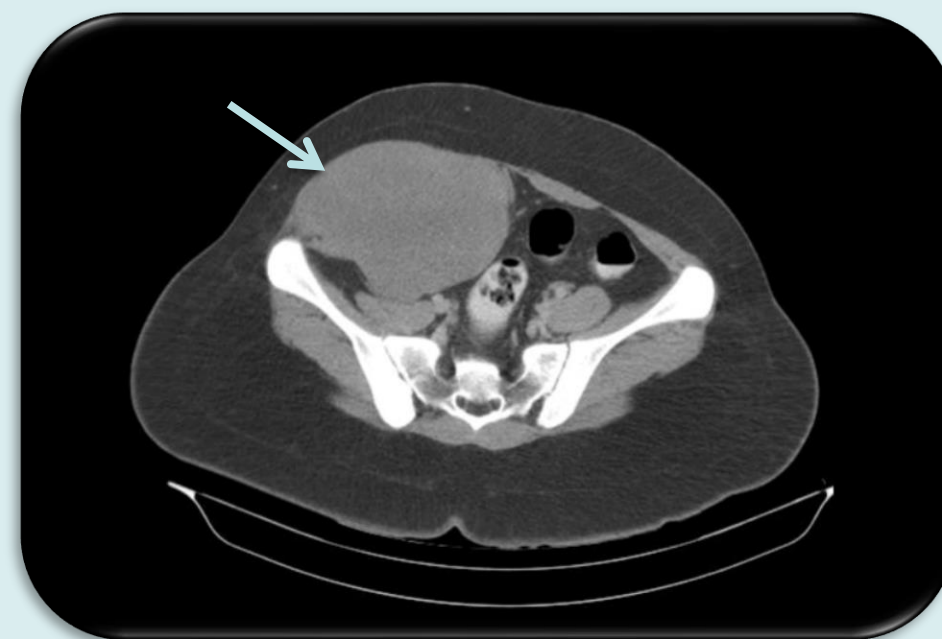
CT abdomen of DT (arrow)
